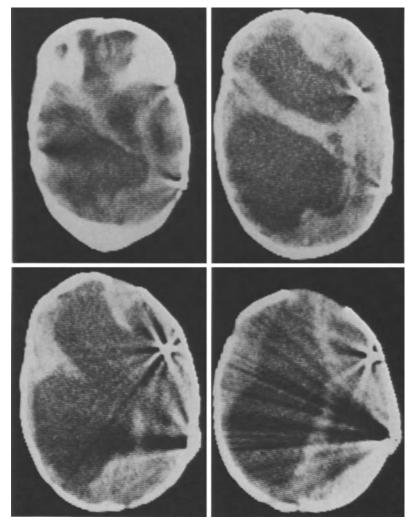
Polycystic transformation (CT Jan. 1, 1979)
